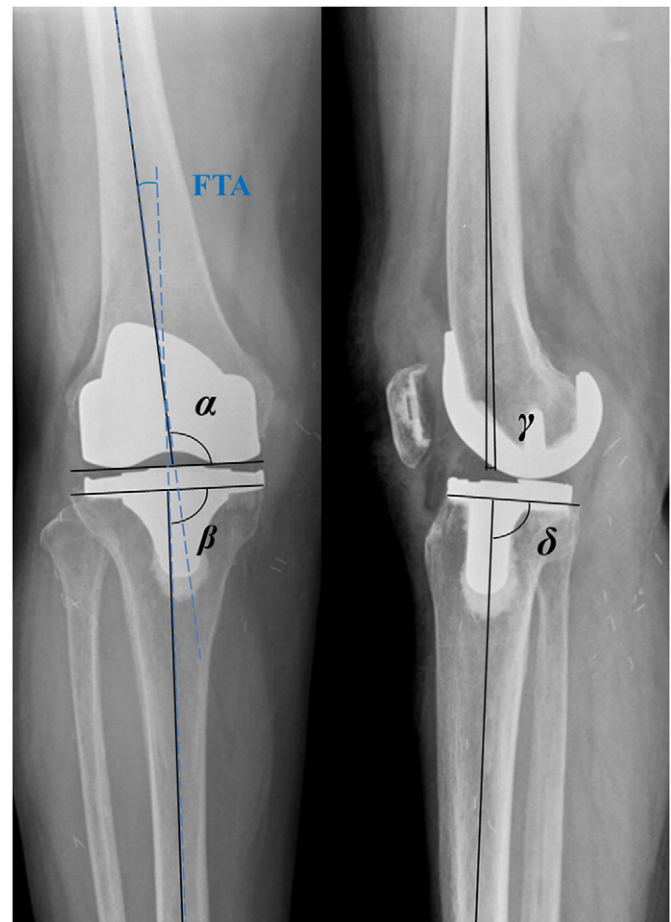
The roentgenographic evaluation method of the American Knee Society is shown. The femorotibial angle (FTA) was defined as the angle between the femoral and tibial anatomical axes. The α and β angles were defined as the coronal femoral and tibial component angles. The γ and δ angles were defined as the sagittal femoral and tibial component angles.
